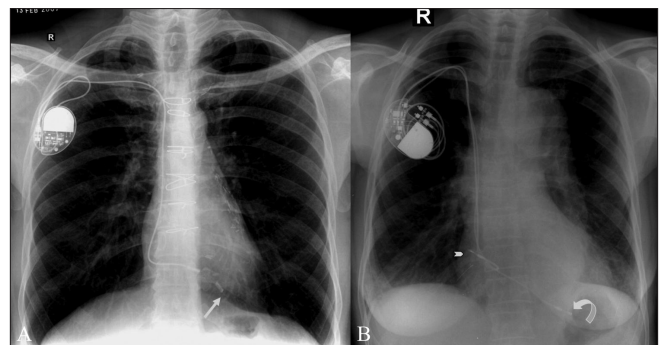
(A, B): Frontal chest radiograph (A) shows the optimal position of the electrode of a single-lead pacemaker. The electrode has been placed in the right ventricular apex (straight arrow). Frontal chest radiograph (B) shows a two-lead pacemaker that has one electrode in the right atrium (arrowhead) and the other at the right ventricular apex (curved arrow)
